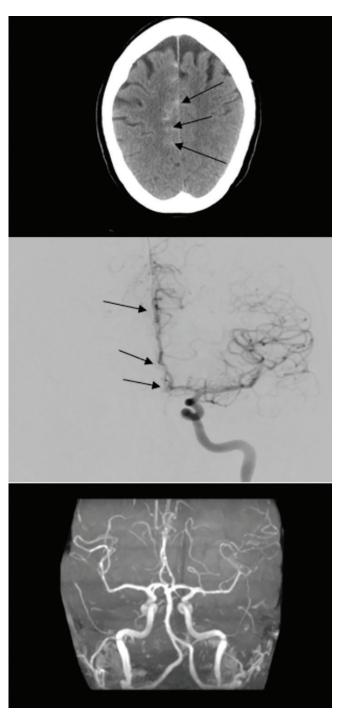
At the time of diagnosis of reversible cerebral vasoconstriction syndrome, CT head shows subarachnoid hemorrhage (arrows) (A) and angiogram shows areas of vasospasm and narrowing along the anterior cerebral artery (arrows) (B). Magnetic resonance angiography at 2-month follow-up shows normalization of blood vessels (C).
